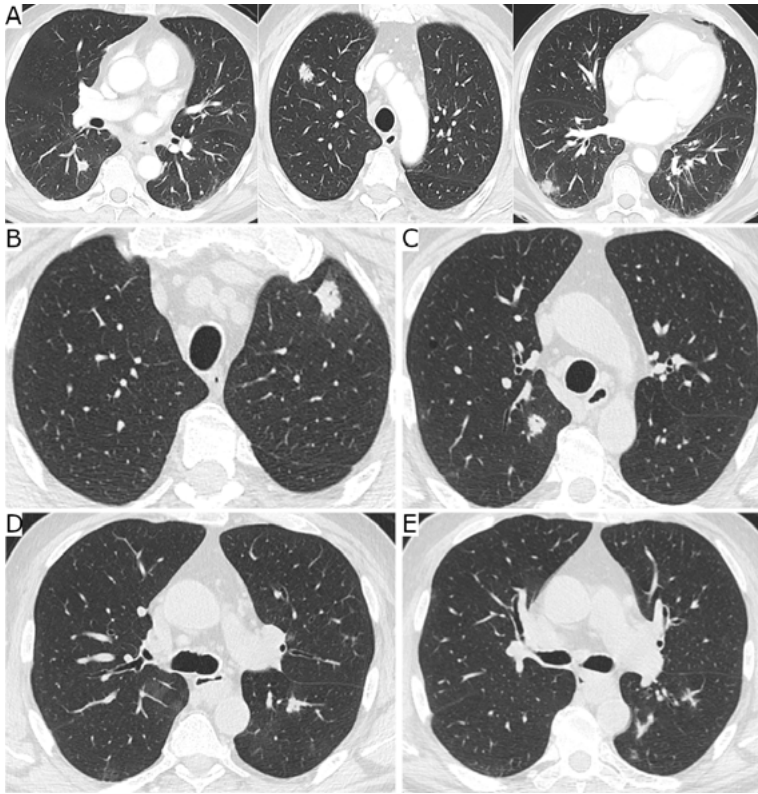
(A) Chest scan (lung window) showing multifocal and asymmetrical parenchymal consolidation with peripheral and subpleural distribution and nodular consolidation with ground glass opacification. (B–E) High-Resolution Computed Tomographic imaging (lung window) showing new consolidation with air-bronchogram (B, C) and nodular consolidation (D, E).
